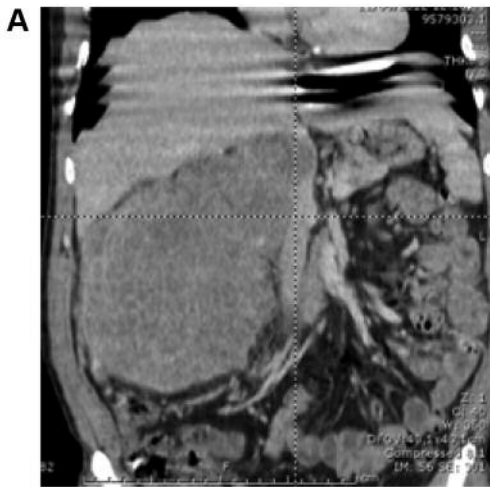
Computed tomographic scan detected a large right renal mass with infiltration and thrombosis of inferior vena cava (A). Coronal scan shows infiltration of vena cava and diaphragm (B).
